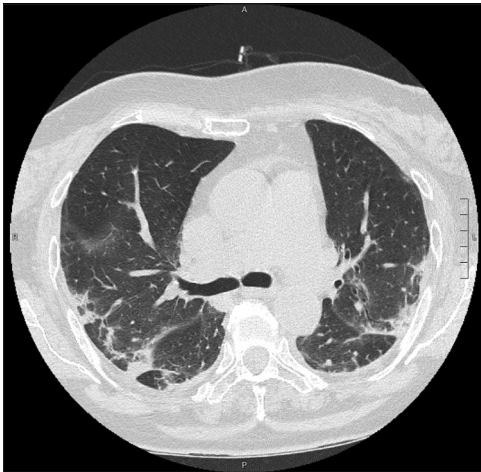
Second patient thorax computed tomography scan
